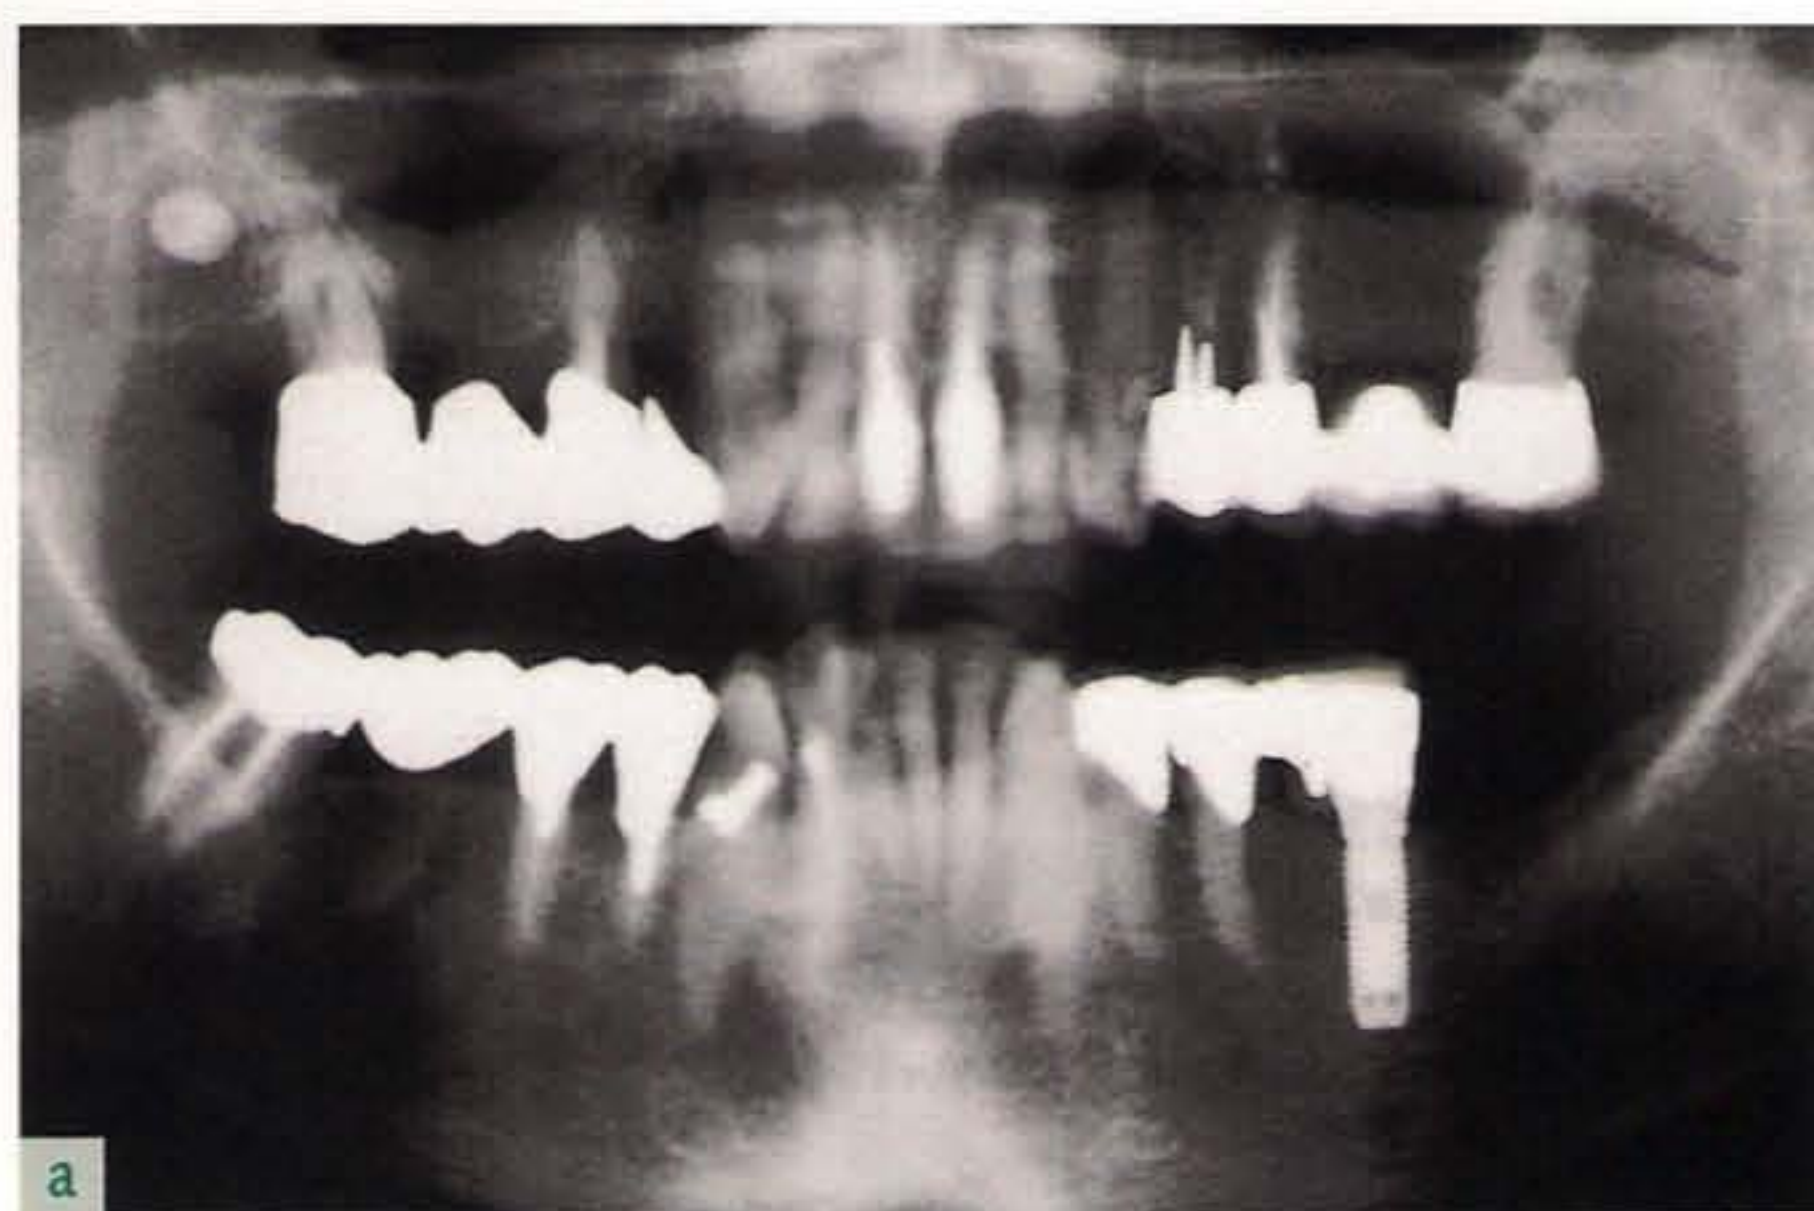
(a) Radiographic view and (b) clinical view of the restoration of a distal edentulous space by means of an implant rigidly connected to two natural abutments.
